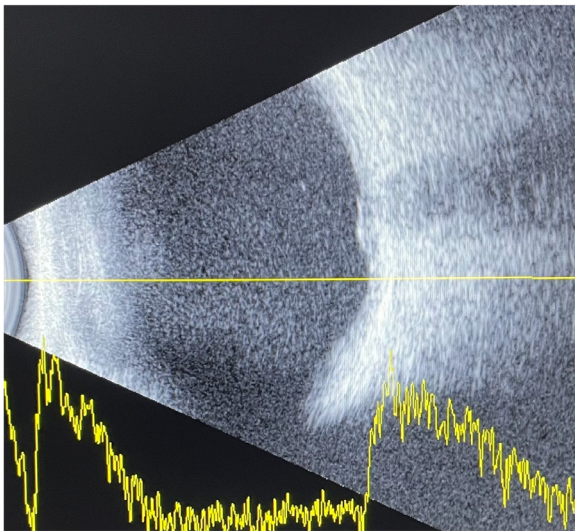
Orbital B-scan ultrasonography of the left eye showing optic disc edema and fluid in the optic nerve sheath.
